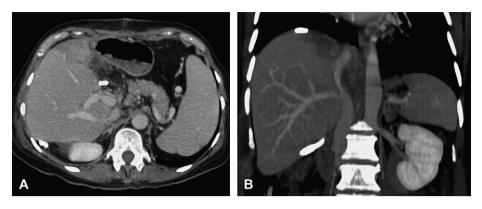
Postoperative computed tomography scan (A) hypertrophy of the remnant liver (segment 6) with patent inferior right hepatic vein and (B) sagittal view of the liver shows exclusive drainage of the remnant liver by inferior right hepatic vein.
